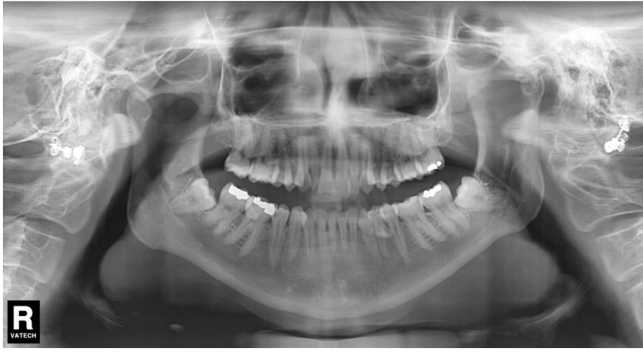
Panoramic radiograph: the lesion does not appear clearly and definitively.
